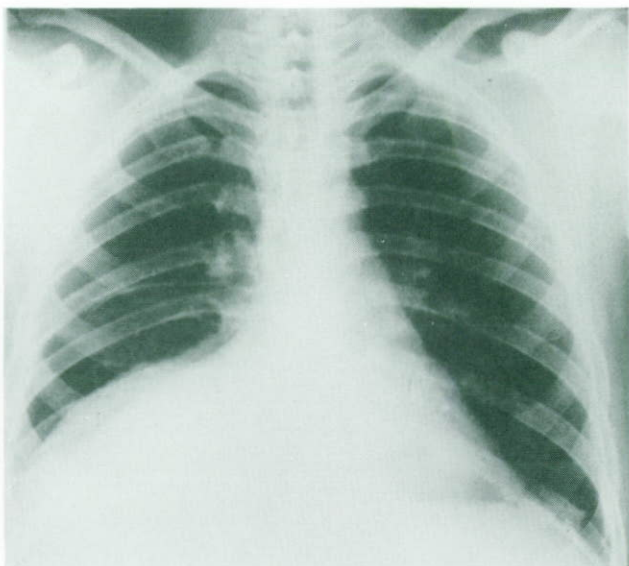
(A) Chest radiograph showing what could be either collapse or subpulmonary effusion. (B) The film is taken with the patient lying on the R side. The effusion has moved to the dependant part of the R hemi-thorax and is demarcated by the horizontal line. (C) The effusion was clearly identified by ultrasound.
